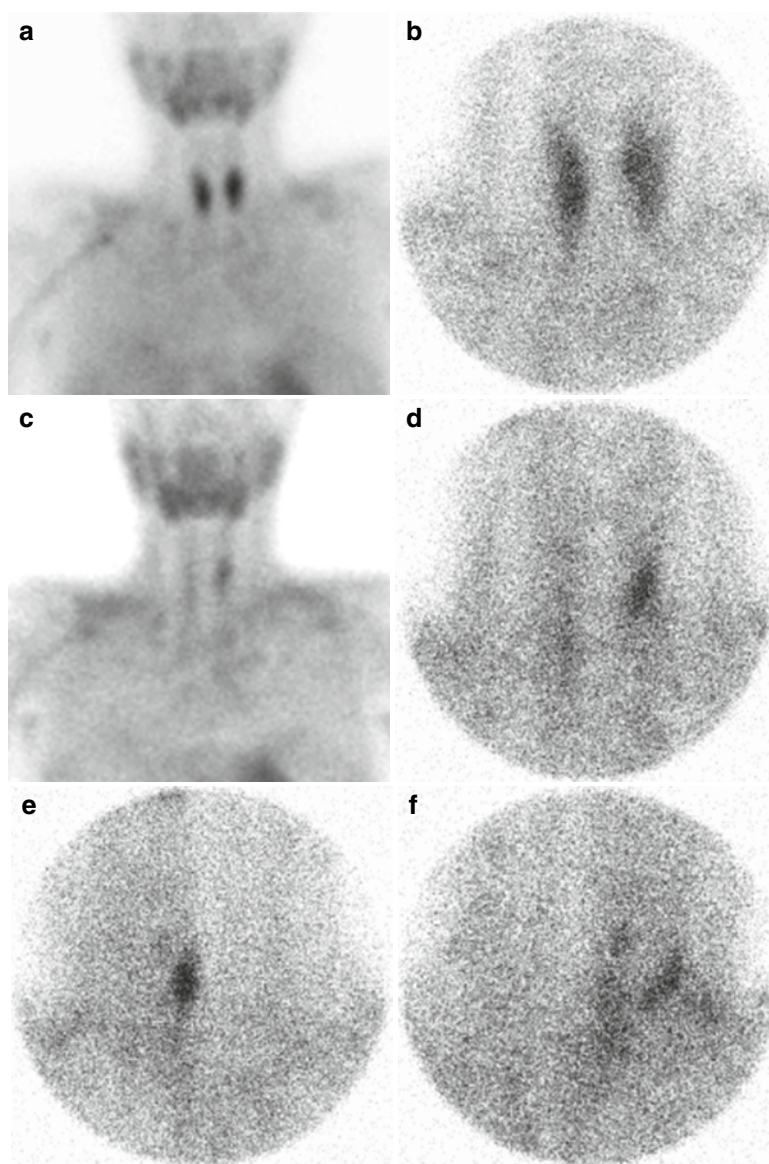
Parathyroid adenoma localized with dual-phase ^{99m}Tc -sestamibi scintigraphy. Planar image of the upper torso and neck (a) and pinhole image of the neck (b) acquired soon after tracer administration show diffuse uptake in the thyroid gland. Two hours later, the planar image (c) and pinhole (d) images demonstrate tracer wash-out from the thyroid gland with persistent ^{99m}Tc -sestamibi
